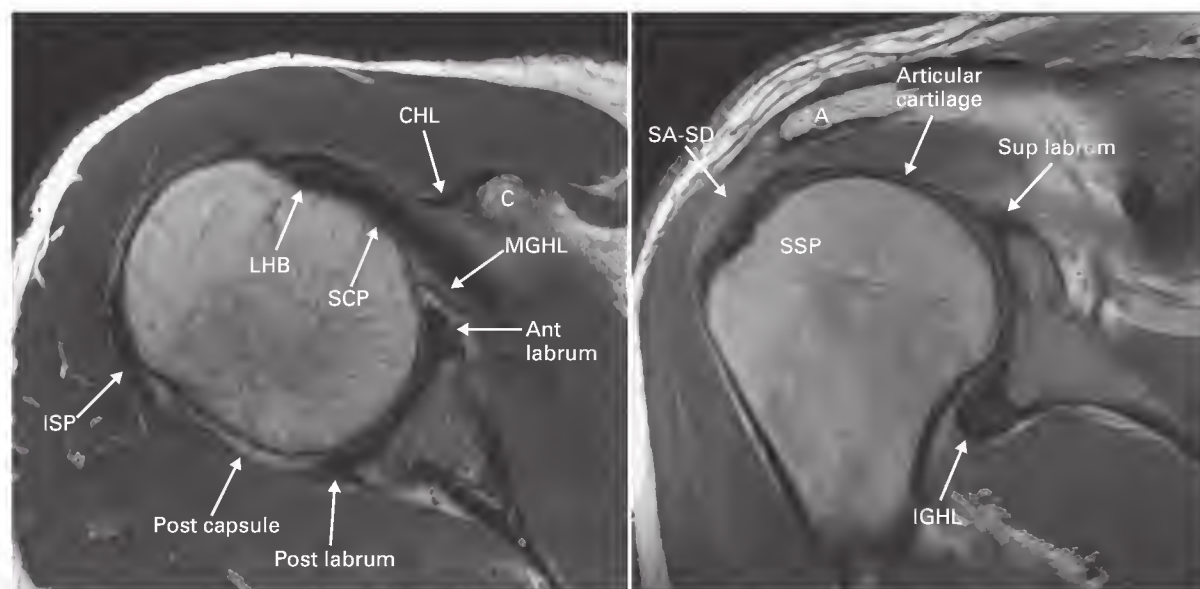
Magnetic resonance imaging of the shoulder showing the anatomic features of the glenohumeral joint. A, acromion; Ant, anterior; C, cyst; CHL, coracohumeral ligament; IGHL, inferior glenohumeral ligament; ISP, infraspinatus; LHB, long head of bicep; MGHL, middle glenohumeral ligament; Post, posterior; SA-SD, subacromial/subdeltoid; SCP, subscapularis; SSP, supraspinatus; Sup, superior.
